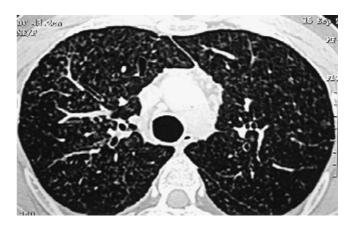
High-resolution thorax CT axial section, multiple thin-walled cyst formations and interlobular septal thickenings are seen.
